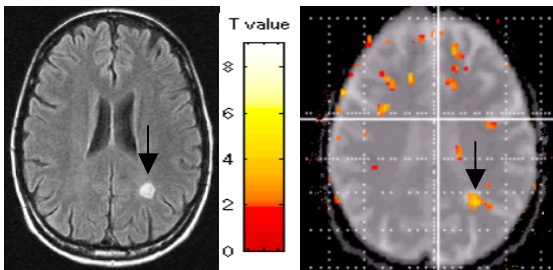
FLAIR image (left) and statistical map overlaid on top of the b=0 diffusion weighted image (right).
